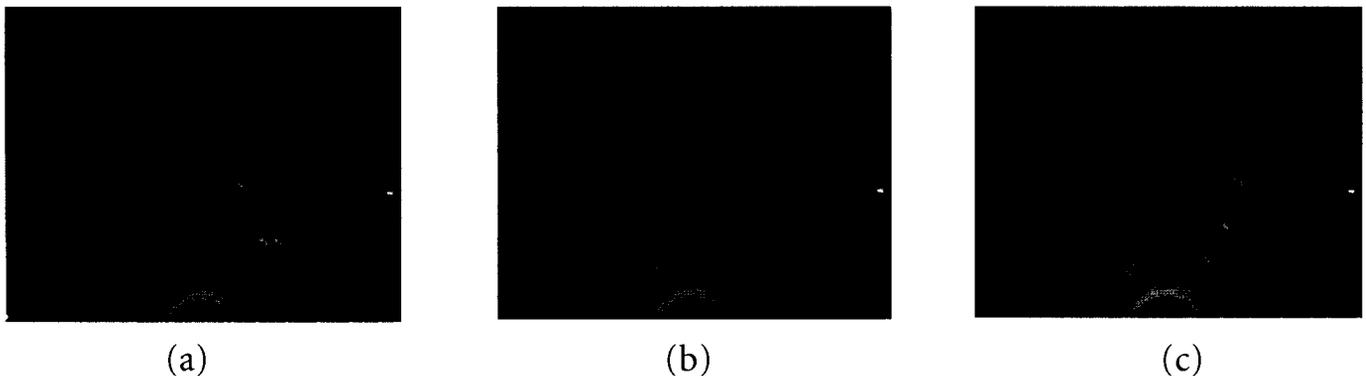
Midsagittal ultrasound contours of the tongue during the production of sustained vowels. The anterior tongue is towards the right side of the images. To facilitate viewing, the tongue contours are marked with a grey line. (a) sustained /a/; (b) sustained /i/; (c) sustained /u/.
